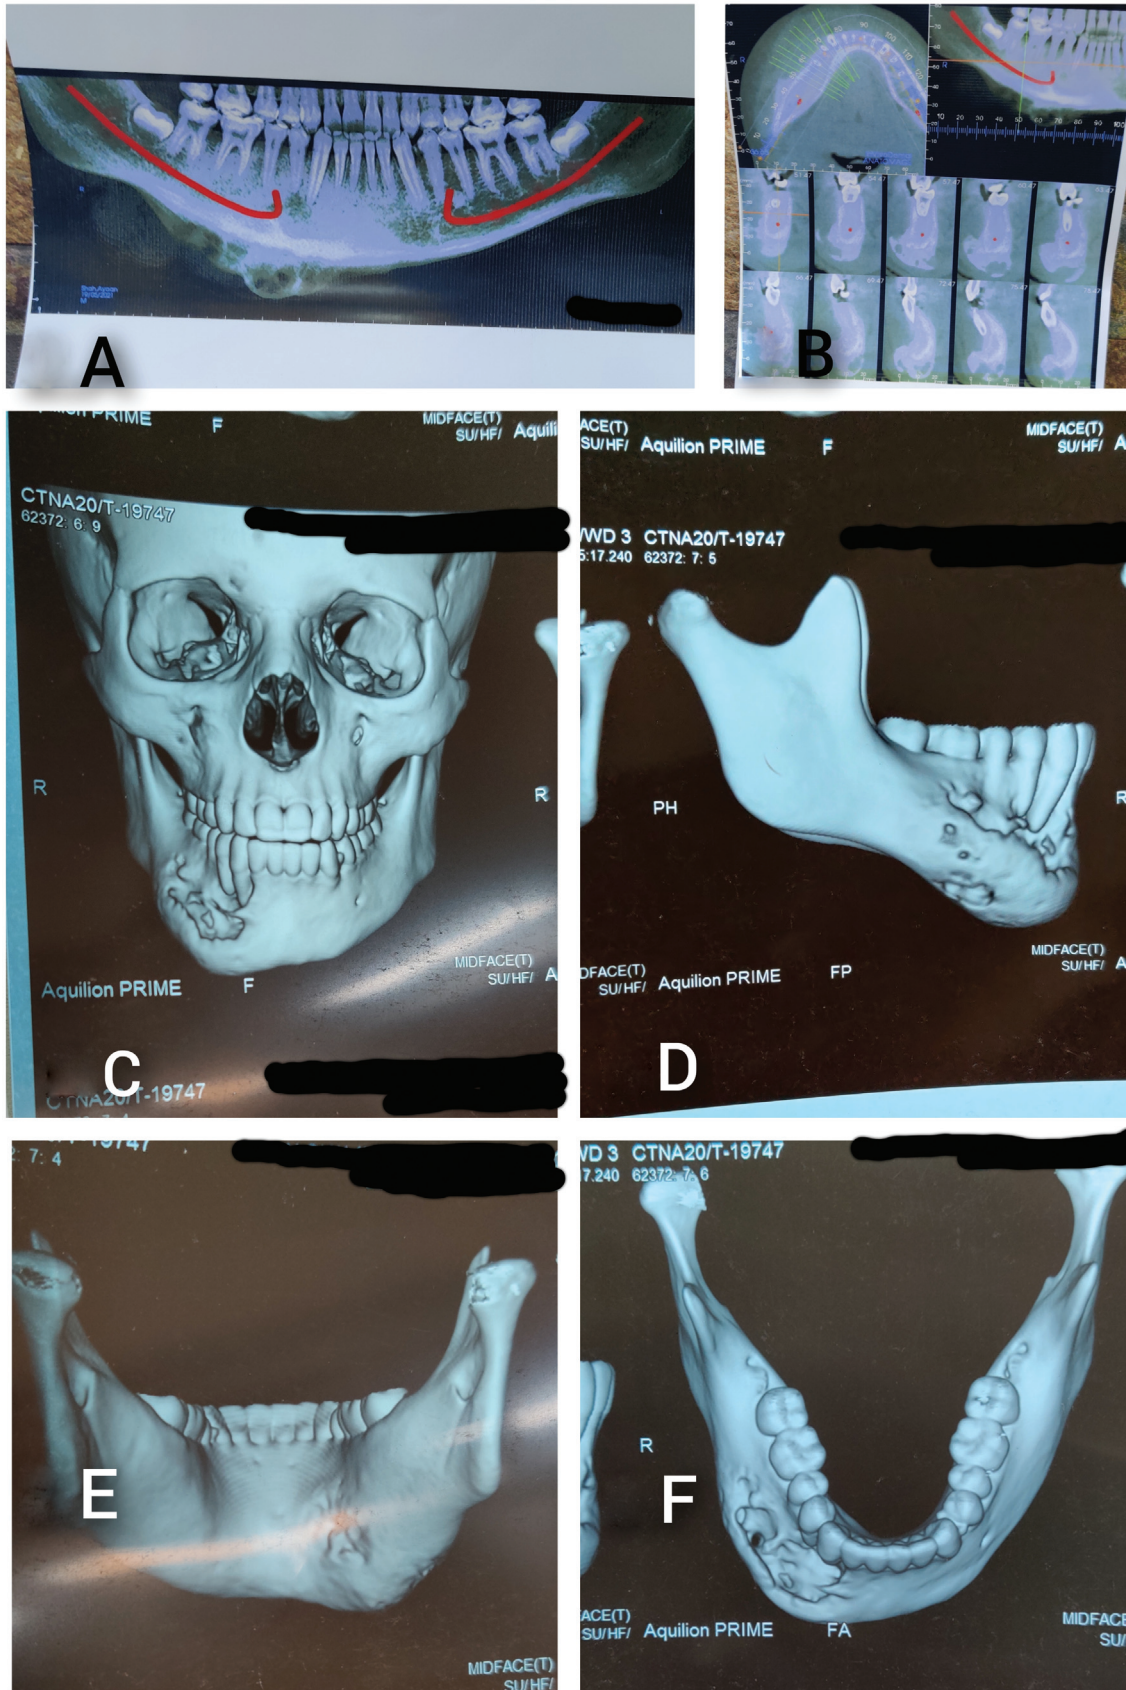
Radiological investigations. (A) Preoperative orthopantomogram showing the multilocular osteolytic lesion of right parasymphysis and body of mandible. (B) Cone beam CT showing the lytic lesion involving right side of the mandible from lateral incisor till first molar. (C) CT three-dimensional reconstruction showing multiloculated osteolytic expansive lesion arising from the right parasymphysis and body of mandible. (D) CT plate showing involvement of anterior cortex of mandible. (E) CT plate showing sparing of posterior cortex of mandible. (F) CT plate showing involvement of right side of the mandible from lateral incisor till first molar. CT, computed tomography.
